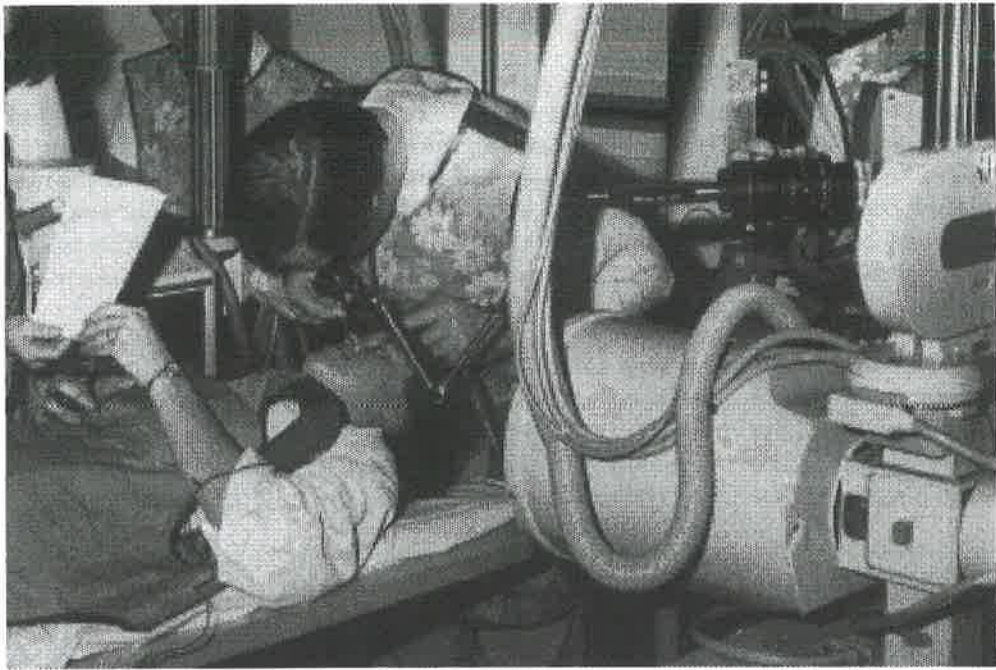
Patient in examination position, supine on x-ray table, head in a soft ring with neck slightly extended. The nasendoscope is being introduced with the Wittmoser arm attached and connected to the colour TV camera. The patient is holding the standard script.
